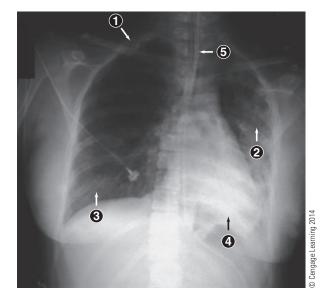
Chest trauma. Rib fracture is noted on the right side (1) of this chest radiograph. Infiltrates of the left side (2) cause a greater density than the right side (3). The diaphragm shadow on the left is lost (4) likely due to pulmonary contusion or possible aspiration pneumonitis. Left-sided atelectasis pulls the mediastinum and trachea (5) to the left. The shift does not appear to be significant, possibly due to patient rotation when radiograph was taken.
